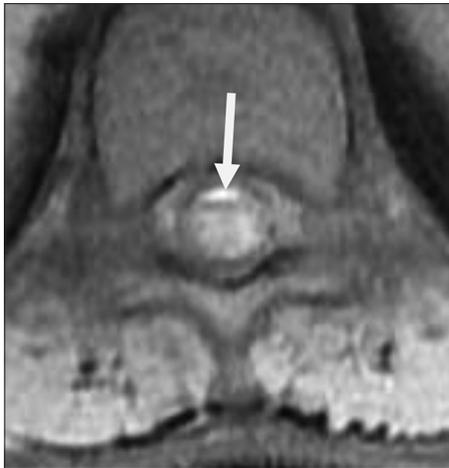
Follow-up magnetic resonance imaging showing minimal residual late subacute subdural hematoma (arrow) showing hyperintense signal on axial T1WI fat sat at T11 level of thickness approximately 2.5 mm
